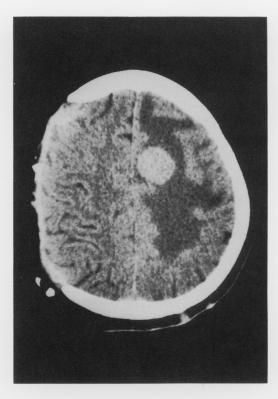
Brain computed tomogram in case 8 demonstrates a round, high-density mass with marked perifocal edema in the left parietal region. Right parietal bone defect is due to previous craniotomy for biopsy.
